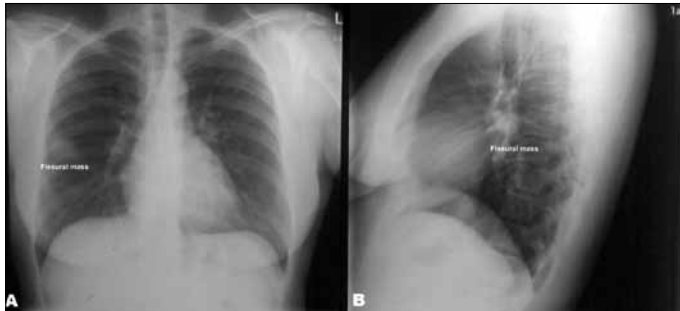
Posteroanterior chest-X-ray showing round-shaped opacity located at right major fissure
